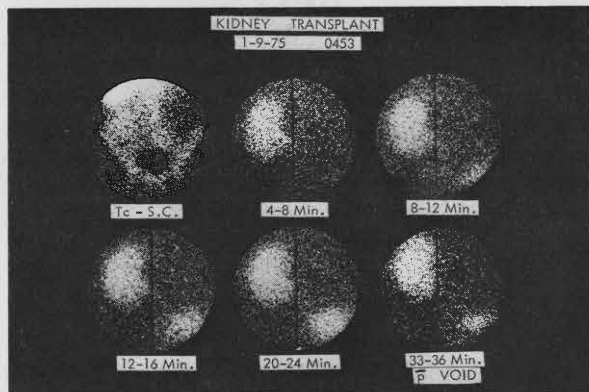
Sulfur colloid and hippurate scintigraphs in chronic rejection.
